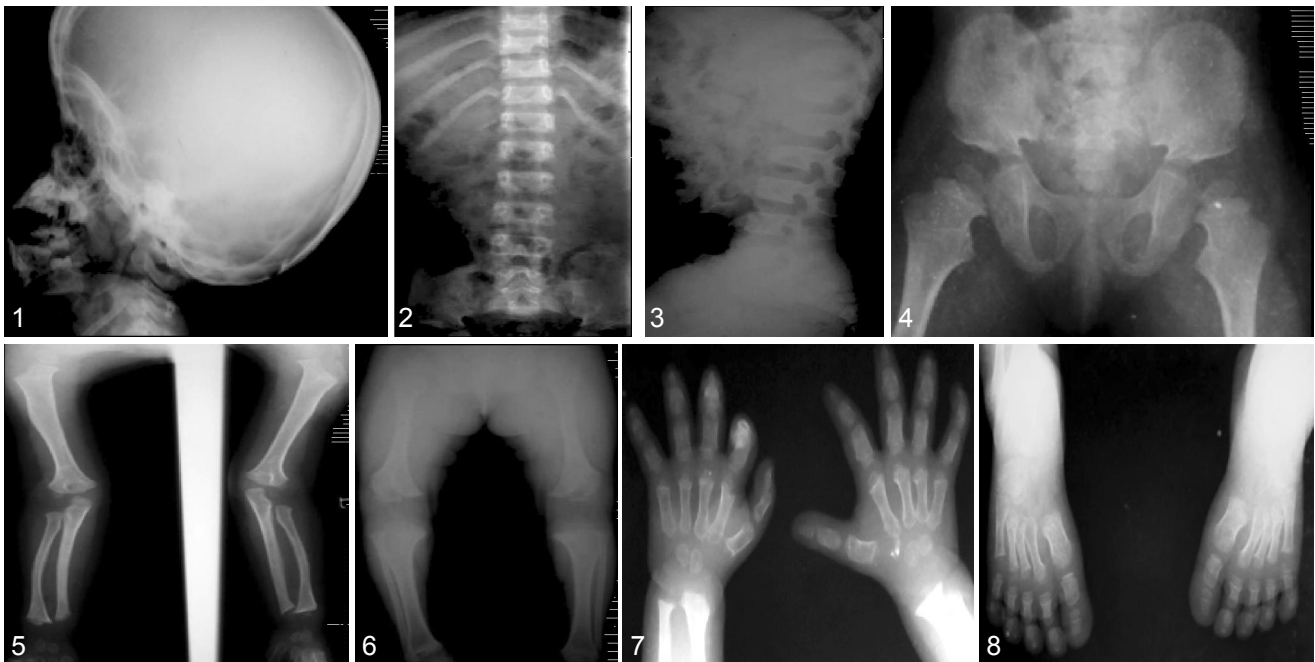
Lateral Skull x-ray, Image 2: Spine (AP), Image 3: Spine (Lateral), Image 4: Pelvis, Image 5: Upper limbs, Image 6: Lower limbs, Image 7: Hands, Image 8: Feet
